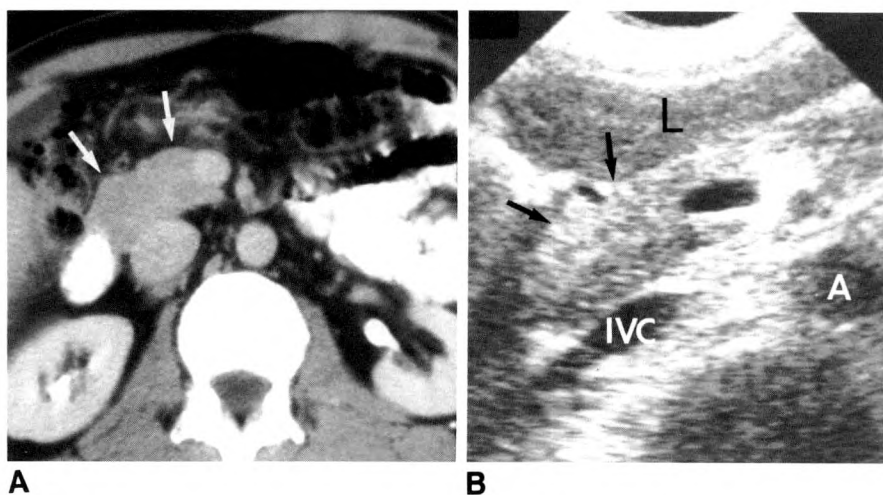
55-year-old man had suspected mass in head of pancreas on CT at another hospital.
